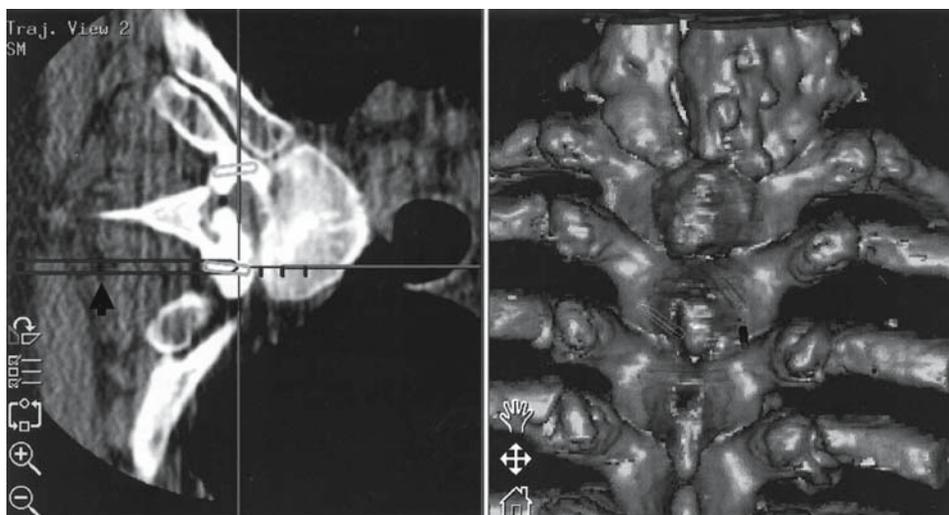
Monitor image of real-time guidance. The tip of the instrument (*arrow*) shows the lateral margins of the area to be resected. Ossification of the ligamentum flavum (OLF) can be seen through the overlying laminae on three-dimensional CT
